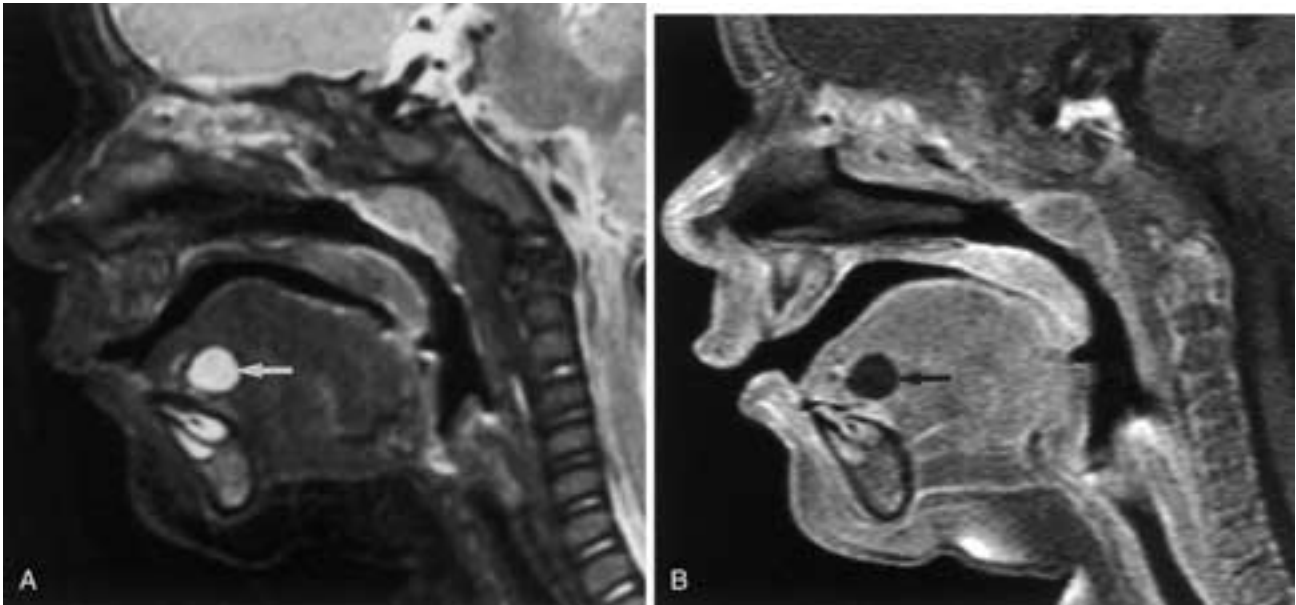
Dermoid cyst in a young child. A, Midline sagittal FSEIR image reveals that the sharply circumscribed cyst (arrow) is isointense with CSF. B, Contrast-enhanced, sagittal T1-weighted MR image reveals the hypointense, nonenhancing dermoid cyst (arrow) in the anterior floor of the mouth.
